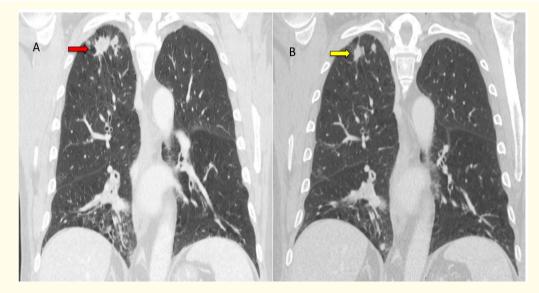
Coronal view from the patient #1 CT chest. Panel A shows the right upper lobe nodule (red arrow) after the patient had finished Itraconazole therapy. Notice the increase in size compared to initial presentation (figure 1A). Panel B shows the decrease in size of the right upper lobe nodule (yellow arrow) 4 months after he had a negative CT guided biopsy.
